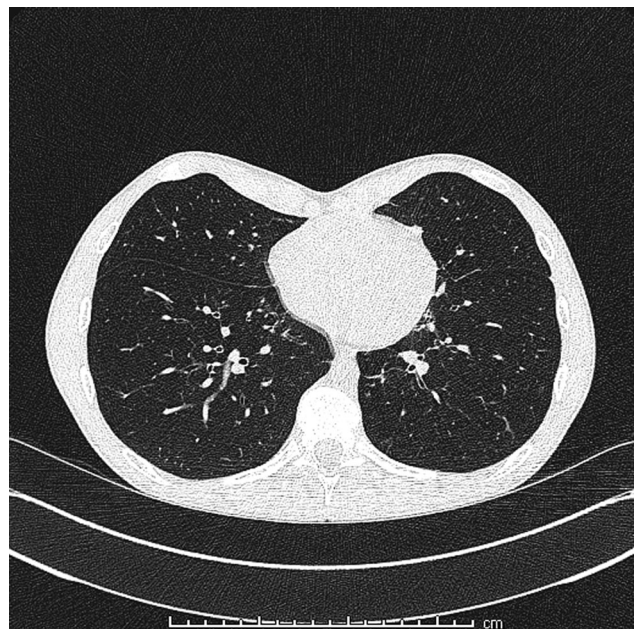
Case 5, chest CT: tree-in-bud opacities in the left lower lobe, air-trapping, and subsegmental bronchiectasis in upper segment of left lower lobe (site of previous pneumonia). CT, computed tomography
